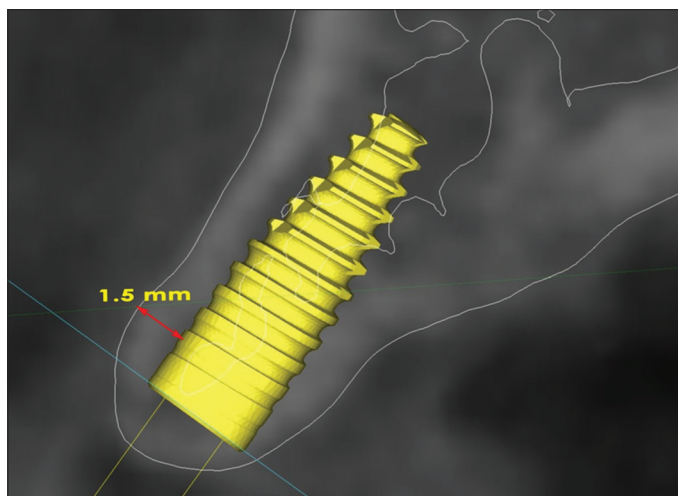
Sagittal view of cone-beam computed tomography with a virtual representation of the implant in site 12, which displays an adequate vestibular bone thickness of 1.5 mm
